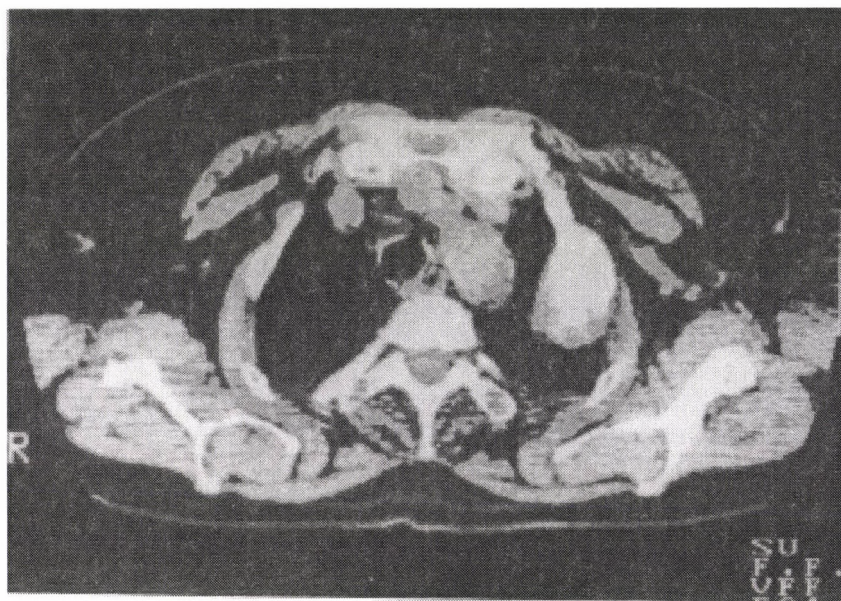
Thorax CT showing cortical irregularity and periosteal reaction
